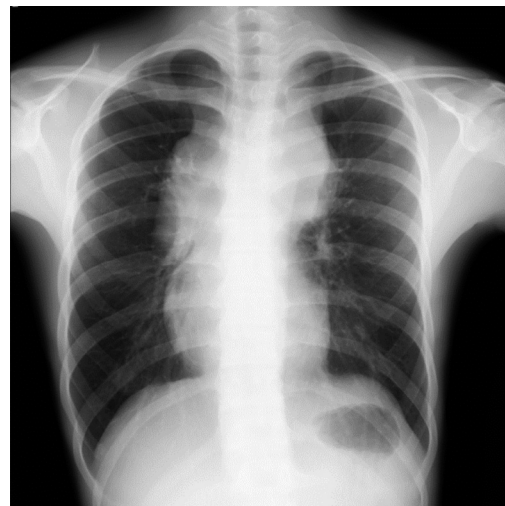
Chest X-ray demonstrated an anterior mediastinal mass.
